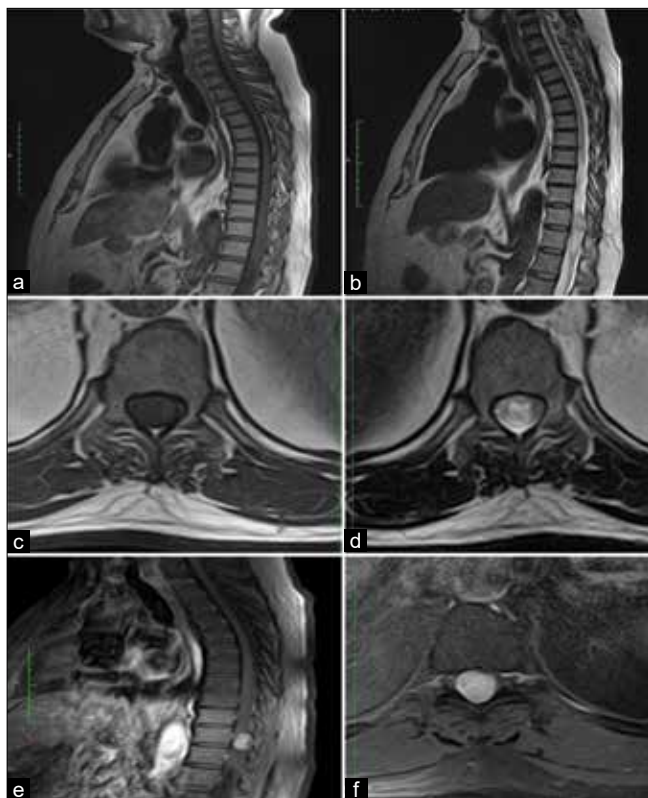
(a and b) (Sagittal T1- and T2-weighted images), (c and d) (Axial T1- and T2-weighted images), (e and f) (Contrast-enhanced sagittal and axial T1-weighted images) showing IM lesion which is isointense on T1, slightly hyperintense on T2 and shows post contrast-enhancement.
